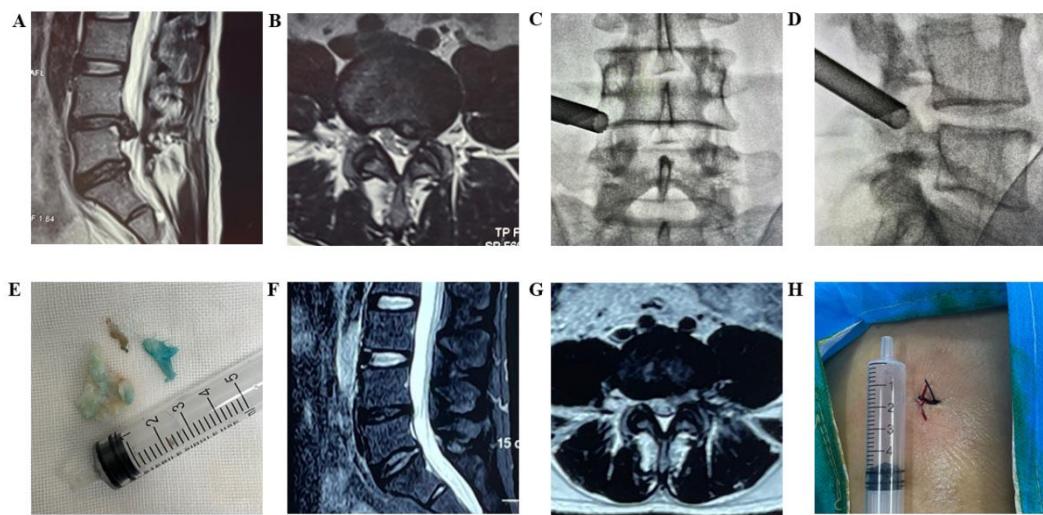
A 40-year-old male patient experienced cramping pain and numbness in the left lower limb for 3 months. (A-B) Lumbar spine MR image showing a paracentral protrusion of the intervertebral disc on the left side at the L4-5 level, which compresses the dural sac and the L5 nerve root. (C-D) The vertebral interspace is accurately positioned in the anteroposterior and lateral views under the C-arm. (E) The free nucleus pulposus
